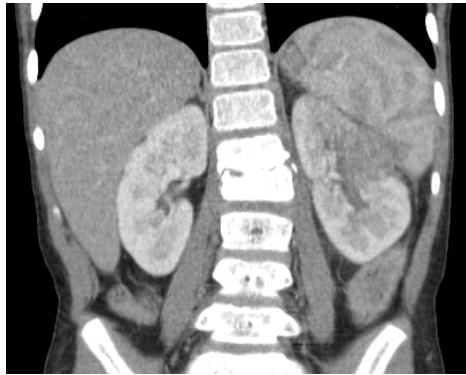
Pelvis CT 05.05.2014*
